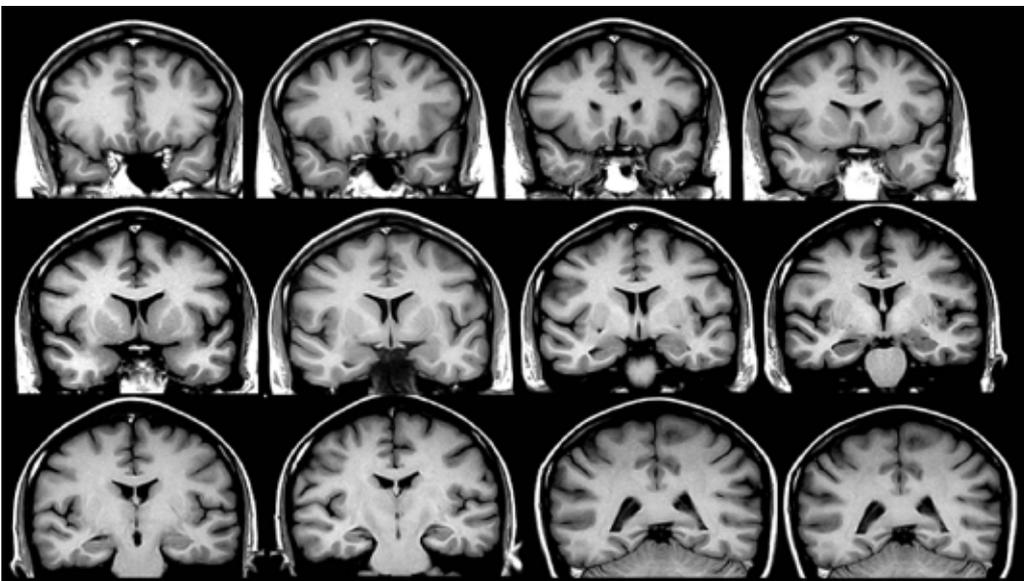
Normal 3D T1 WI MRI in coronal slices volumetric acquisitions.
